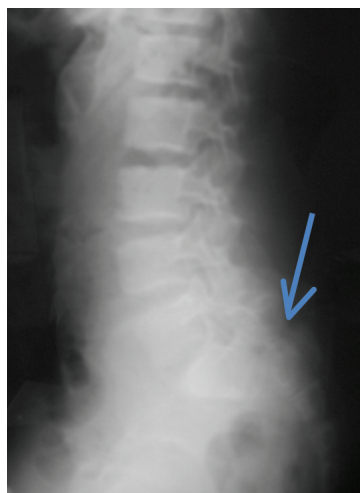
Plain radiography showing dislocation of S1 and S2 (blue arrow), which could easily be missed.
